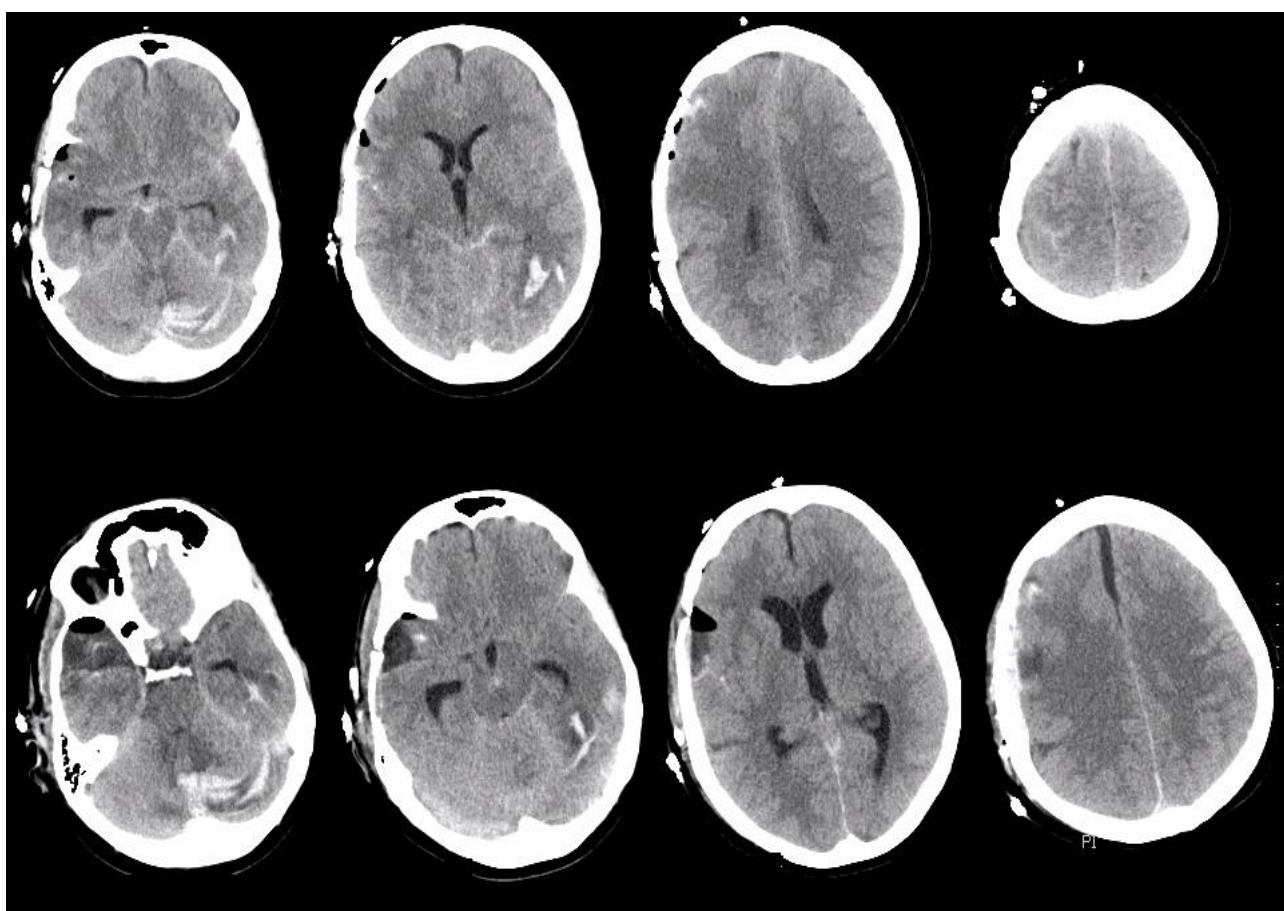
Postoperative axial non-contrast-enhanced computed tomography (CT) shows signs of supra and infratentorial subarachnoidal hemorrhages linked with left temporooccipital intraparenchymal hematoma (Department of Radiology, Clinical Center University of Sarajevo 2020.)
